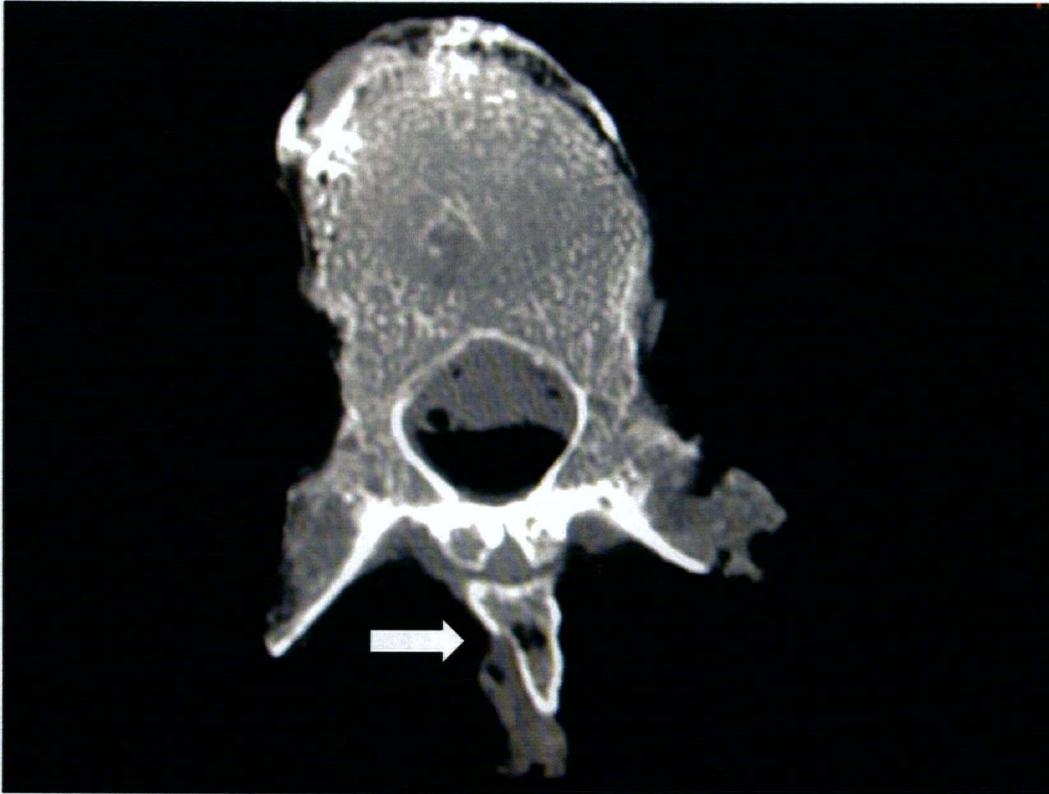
Post test CT scan detected 6 of the 12 fractures. The neuroradiologist interpreted the step in the cortical bone (see arrow) as a fracture.*
